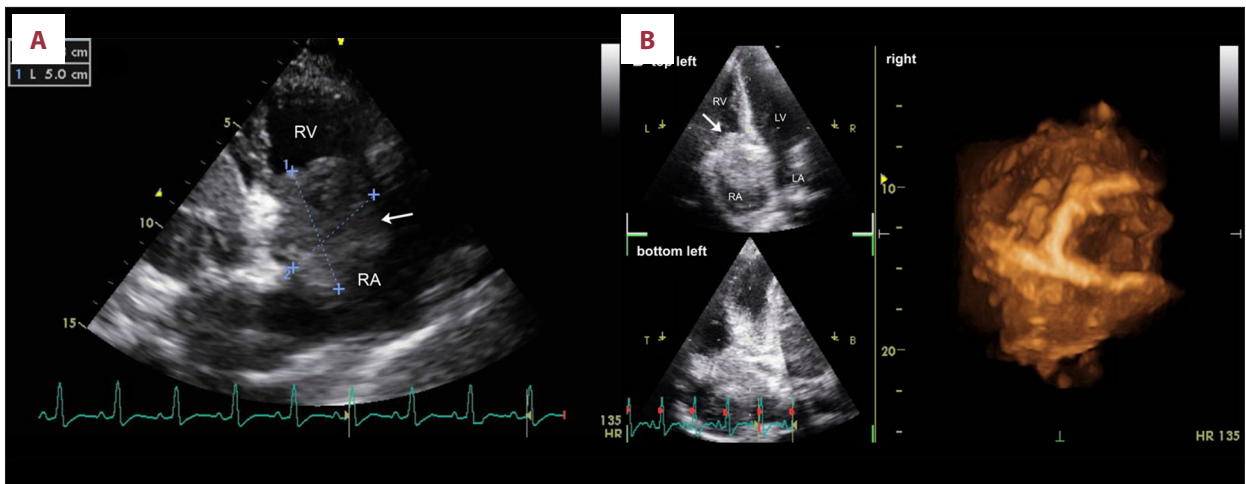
(A) Pretreatment 2-dimensional TTE shows a 5×4.3-cm right atrial mass (arrow) (crosshairs represent dimension measurements). (B) Apical 4-chamber view (top left) of the mass (arrow) and another image plane (bottom left) combined to generate a 3-dimensional reconstruction of the mass (right). LA – left atrium; LV – left ventricle; RA – right atrium; RV – right ventricle.
